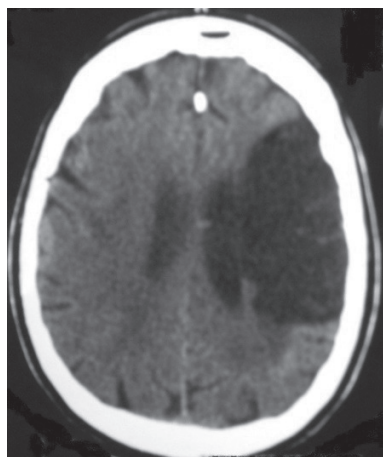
Computed tomography showing an extensive stroke of the middle cerebral artery, affecting more than one cerebral lobe
